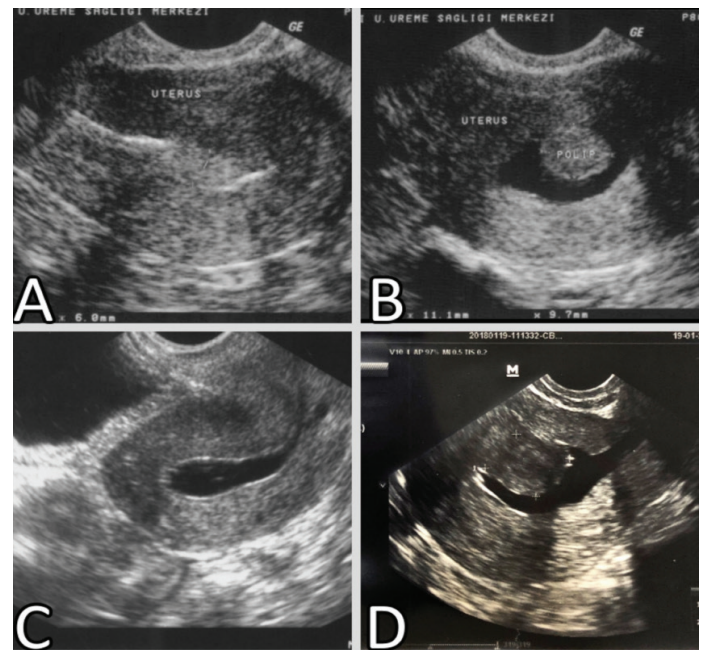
Transvaginal and saline infusion sonography of lesions. A. Endometrial polyp on transvaginal sonography B. Endometrial polyp on saline infusion sonography (A and B belongs to the same patient) C. Normal appearance on saline infusion sonography D. Submucous fibroid on saline infusion sonography
